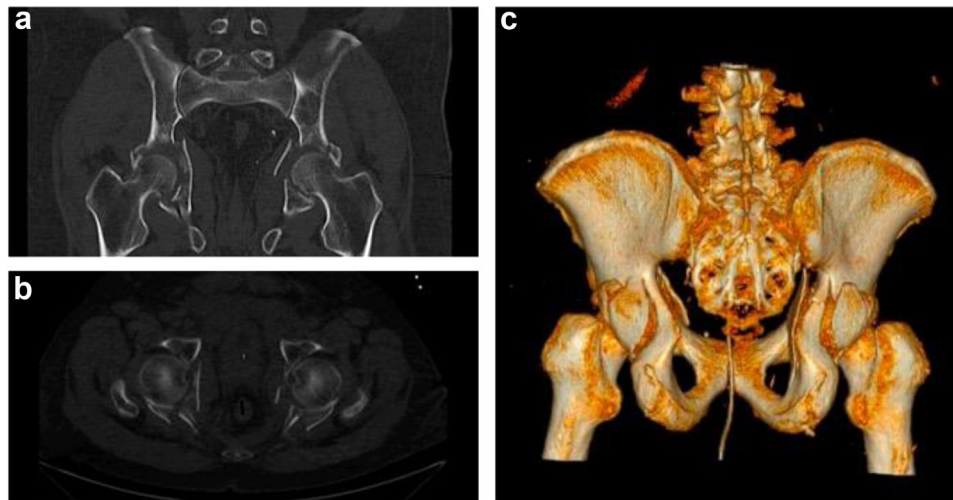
Computed tomography of the pelvis: (a) coronal view, (b) axial view, (c) 3D reconstruction.
